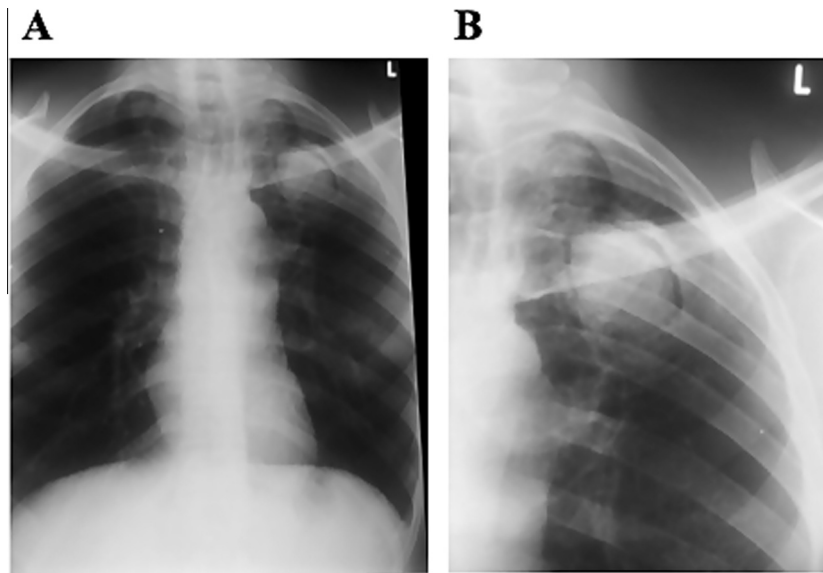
(A) Chest radiograph showing fungal ball in the left apical lung taken at initial diagnosis; (B) 5 months into treatment with 200 mg of daily itraconazole showing the aspergilloma.
